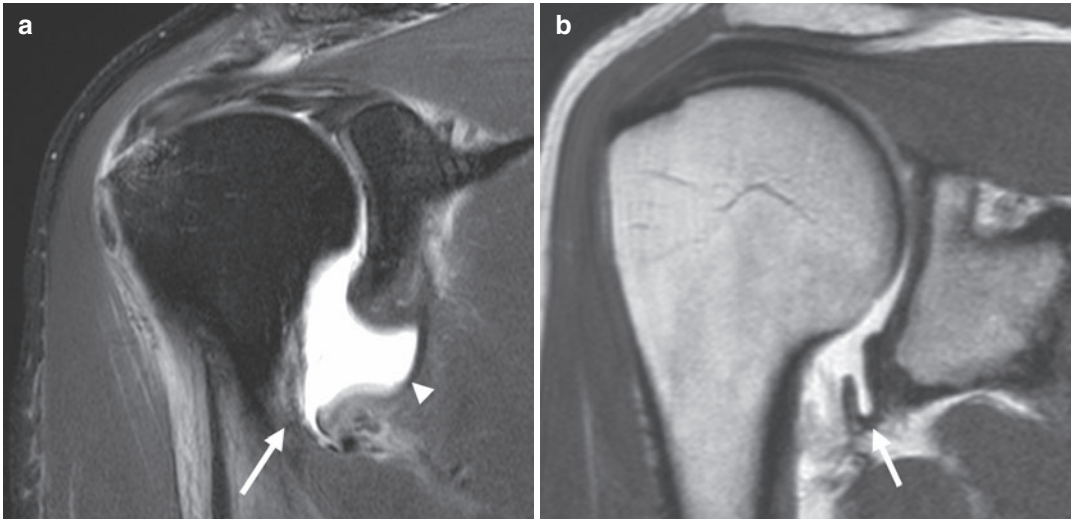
(a) Coronal T1-weighted MR arthrogram with fat suppression: The black line corresponds to the glenoid plane. The white arrow points on the medially displaced and scarred anteroinferior labrum in an anterior labrum periosteal sleeve avulsion (ALPSA). (b) Corresponding
